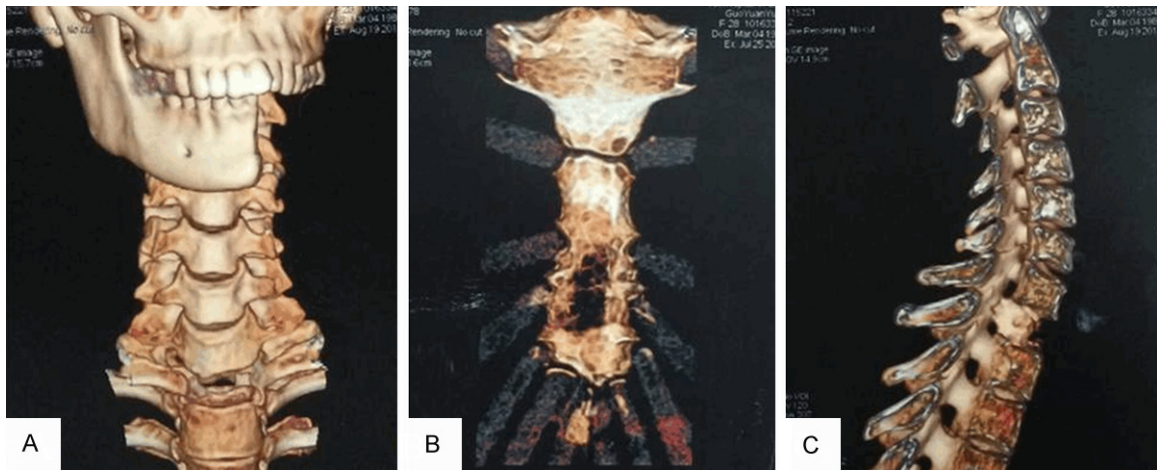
Computed tomographic scan of the chest. A. The left mandible missed. B. The lytic lesion of the sternum. C. The lytic lesion of the first thoracic vertebra.
